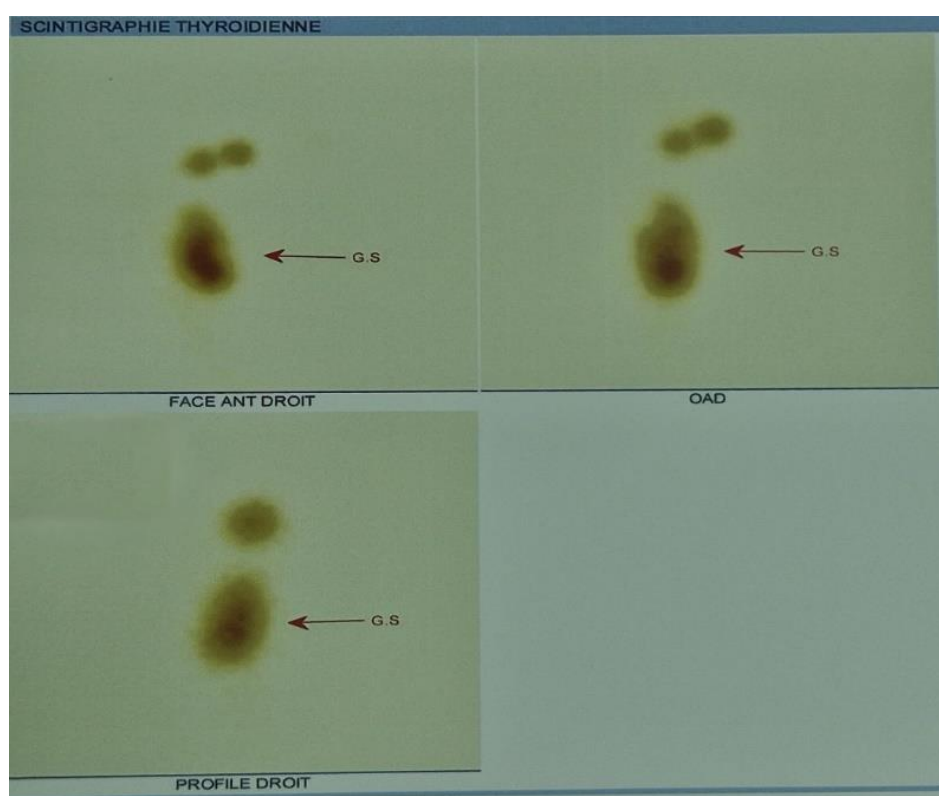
Lymphoscintigraphy in three static projections
